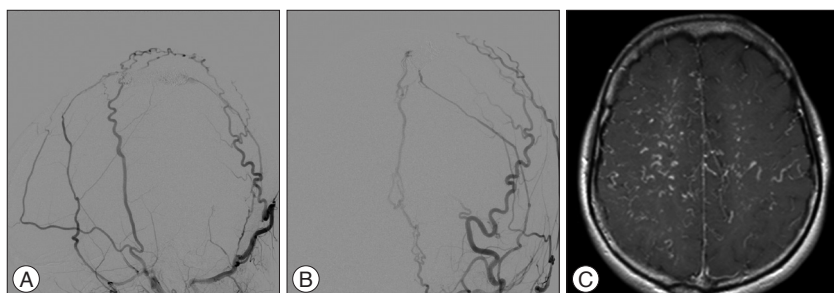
A and B : Post-embolization angiography shows the disappearance of the dural arteriovenous fistula at the mid-portion of the superior sagittal sinus. C : Postoperative MRI shows an interval improvement of the dilated cortical veins.
